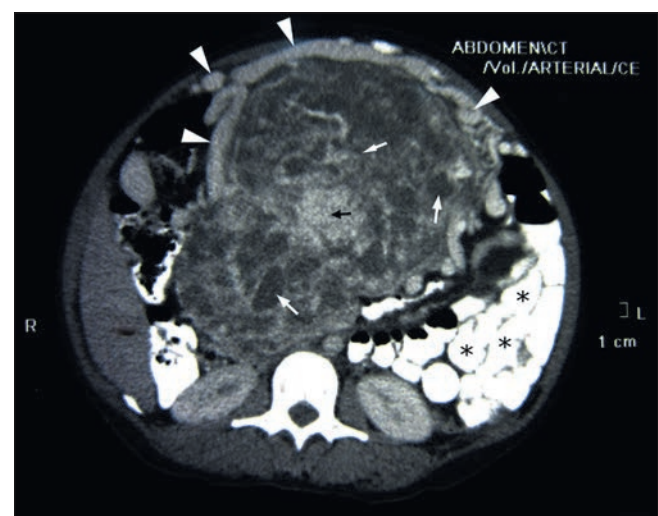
Computed tomography scan. Axial cuts of the abdominal tumour demonstrate large surface arteries (arrow heads) and huge vascular (black arrow) and cystic spaces (white arrows) in the tumour. Small bowel is displaced to the left inferior part of the abdominal cavity (asterisks).
